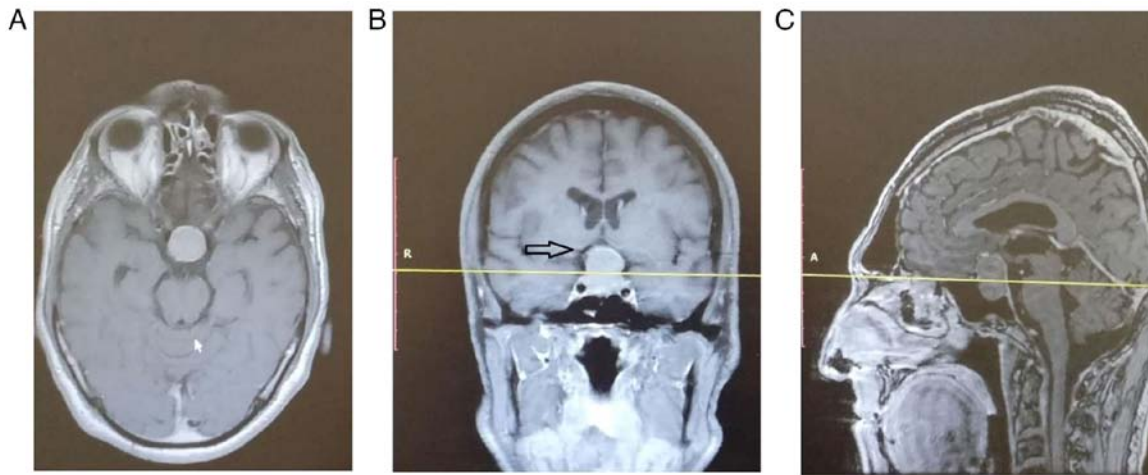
(A-C) Pre-operative contrast enhanced T1 MRI scan of patient 2, depicting a large pituitary macroadenoma that compresses the optic chiasma (arrow).
